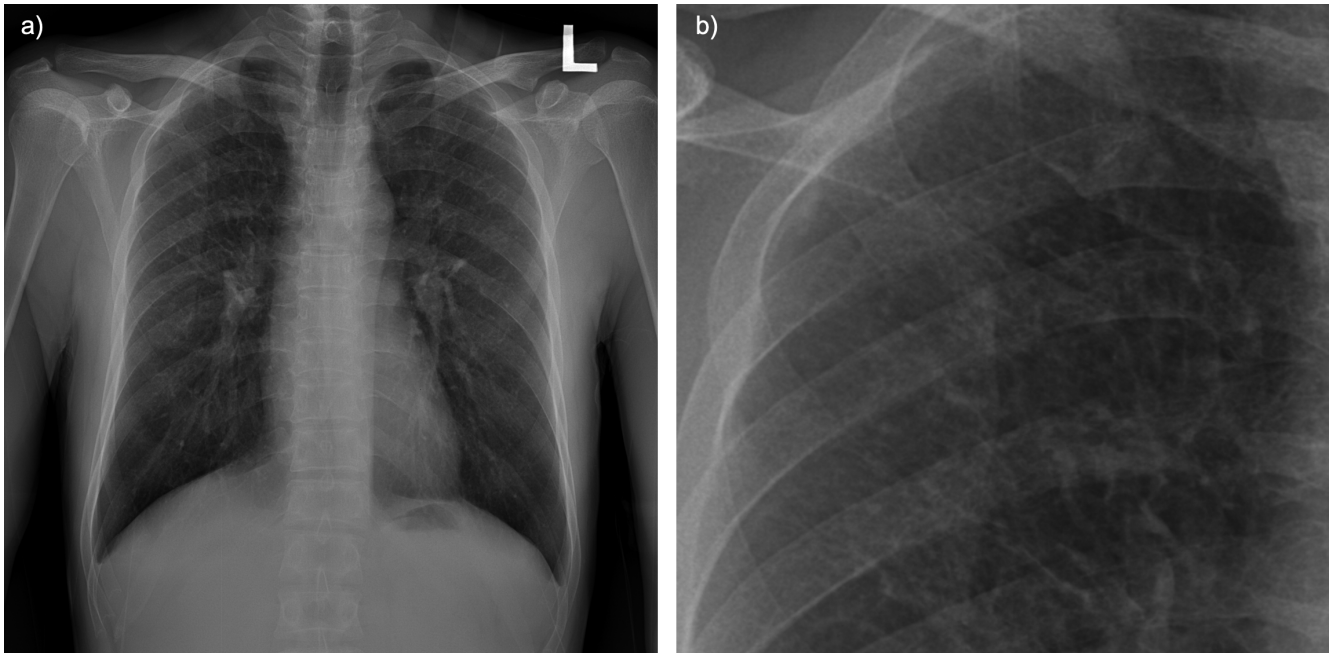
Patient # 4. a) Chest radiograph (posteroanterior) showing a profusion of p/p 2/3. b) Magnification of the chest radiograph.
